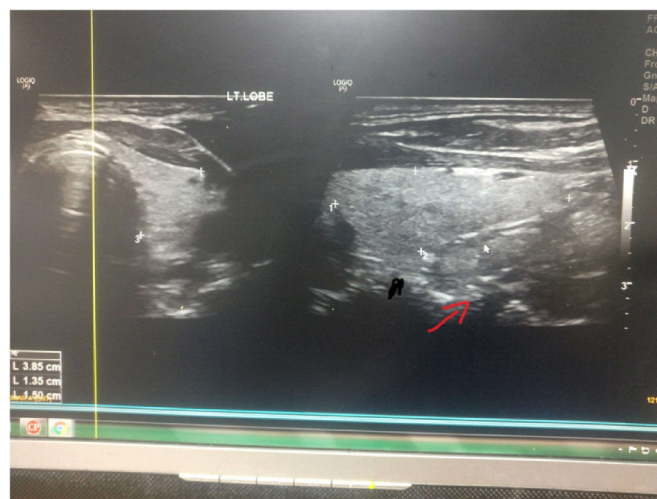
Arrow shows ultrasound picture of the cyst and the left lobe of thyroid.
